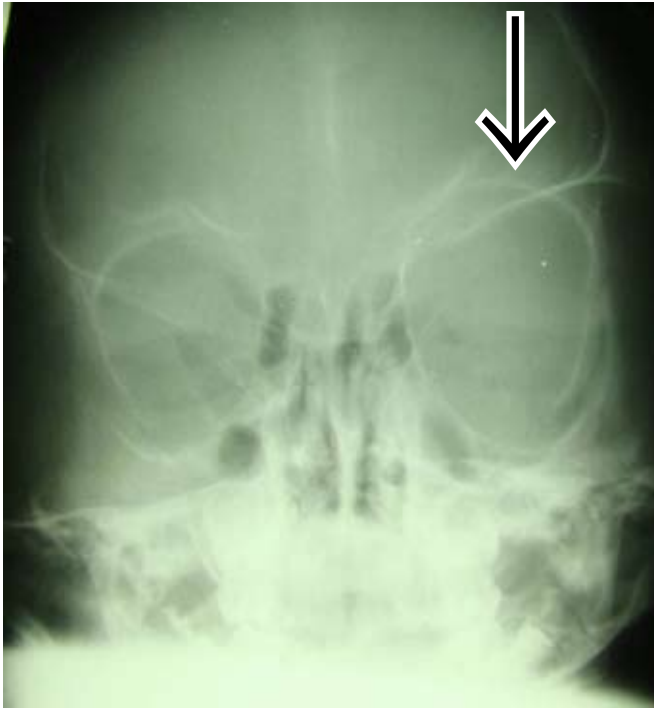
Frontal X-ray of the skull showing harlequin appearance of the left orbit owing to hypoplasia of the greater wing of the sphenoid bone.
